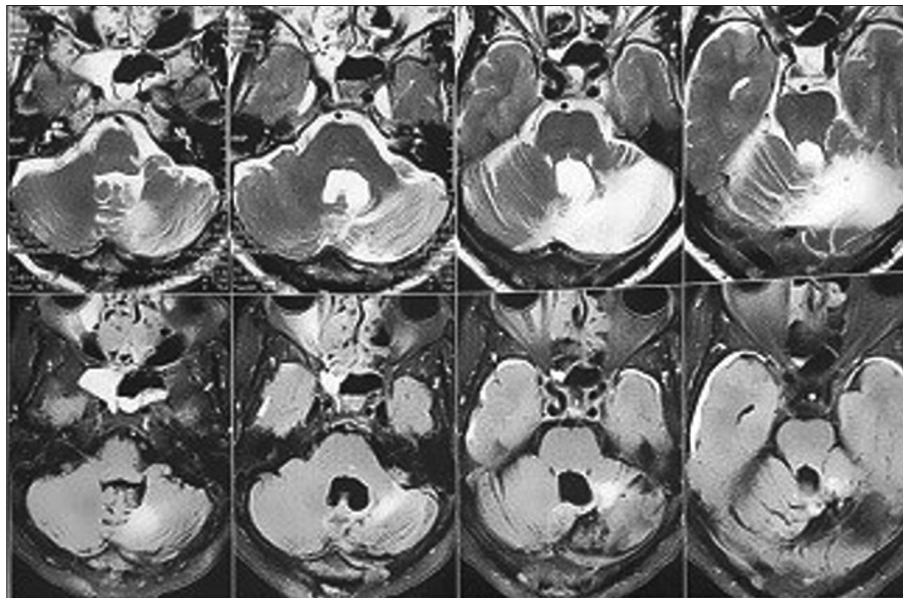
Post-operative brain magnetic resonance images of case 2. Axial T2-weighted images (top row) and FLAIR images (bottom row) show no recurrence nor residual tumor.
